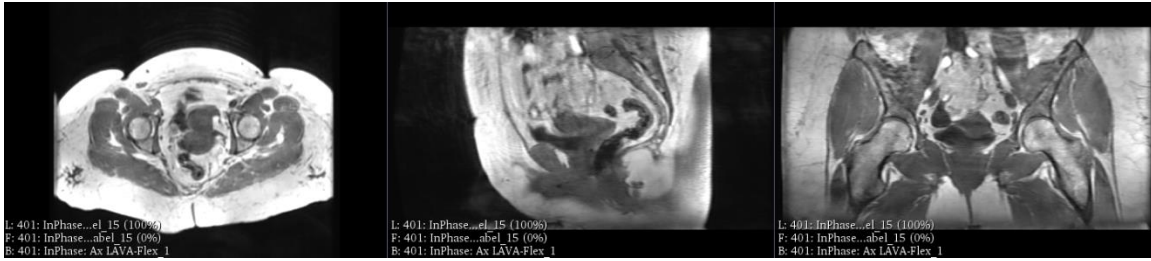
Pelvis MRI (InPhase sequence)
